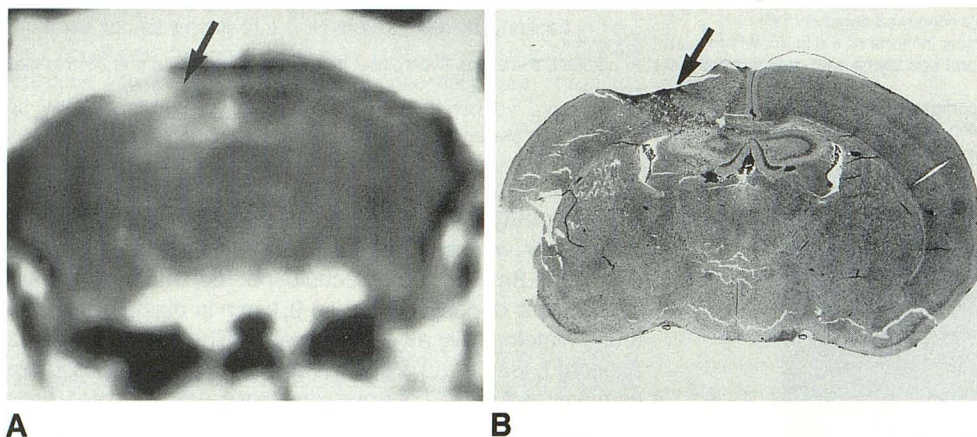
Comparison of MR image with whole brain mount 8 days after intracerebral injection of 50,000 KHT sarcoma cells.
